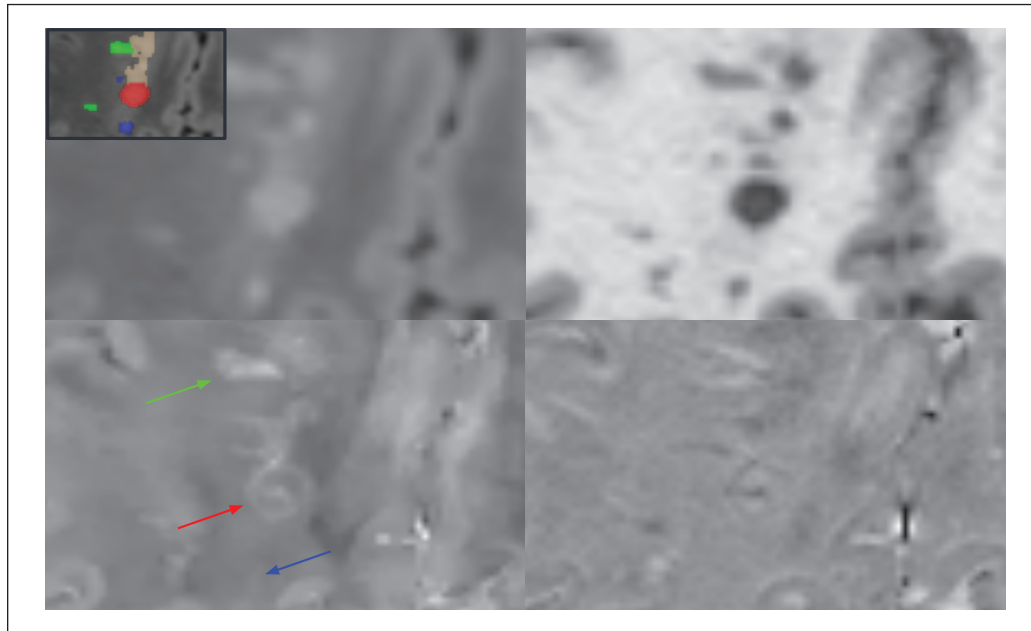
Axial slice of a FLAIR image (top left), MP2RAGE (top right), QSM (bottom left), and PU (bottom right). The same FLAIR image appears in the thumbnail with the manual lesion mask overlaid, presenting QSM phenotypes with different colors: red for PRL, green for hyper-intense, blue for iso-/hypo-intense, and light brown for unclassified components. The QSM image shows arrows pointing to an example of each class used during training.
